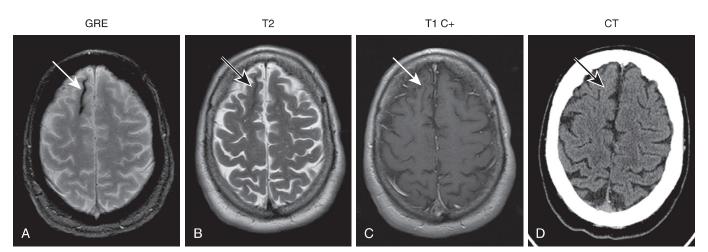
Chronic collapsed posthemorrhagic cavity. Axial magnetic resonance images (A–C) and computed tomography (CT) image (D) of the brain demonstrate hemosiderin within a thin collapsed T2 and T1 hypointense posthemorrhagic cavity barely visible on the CT image. GRE, Gradient echo.
